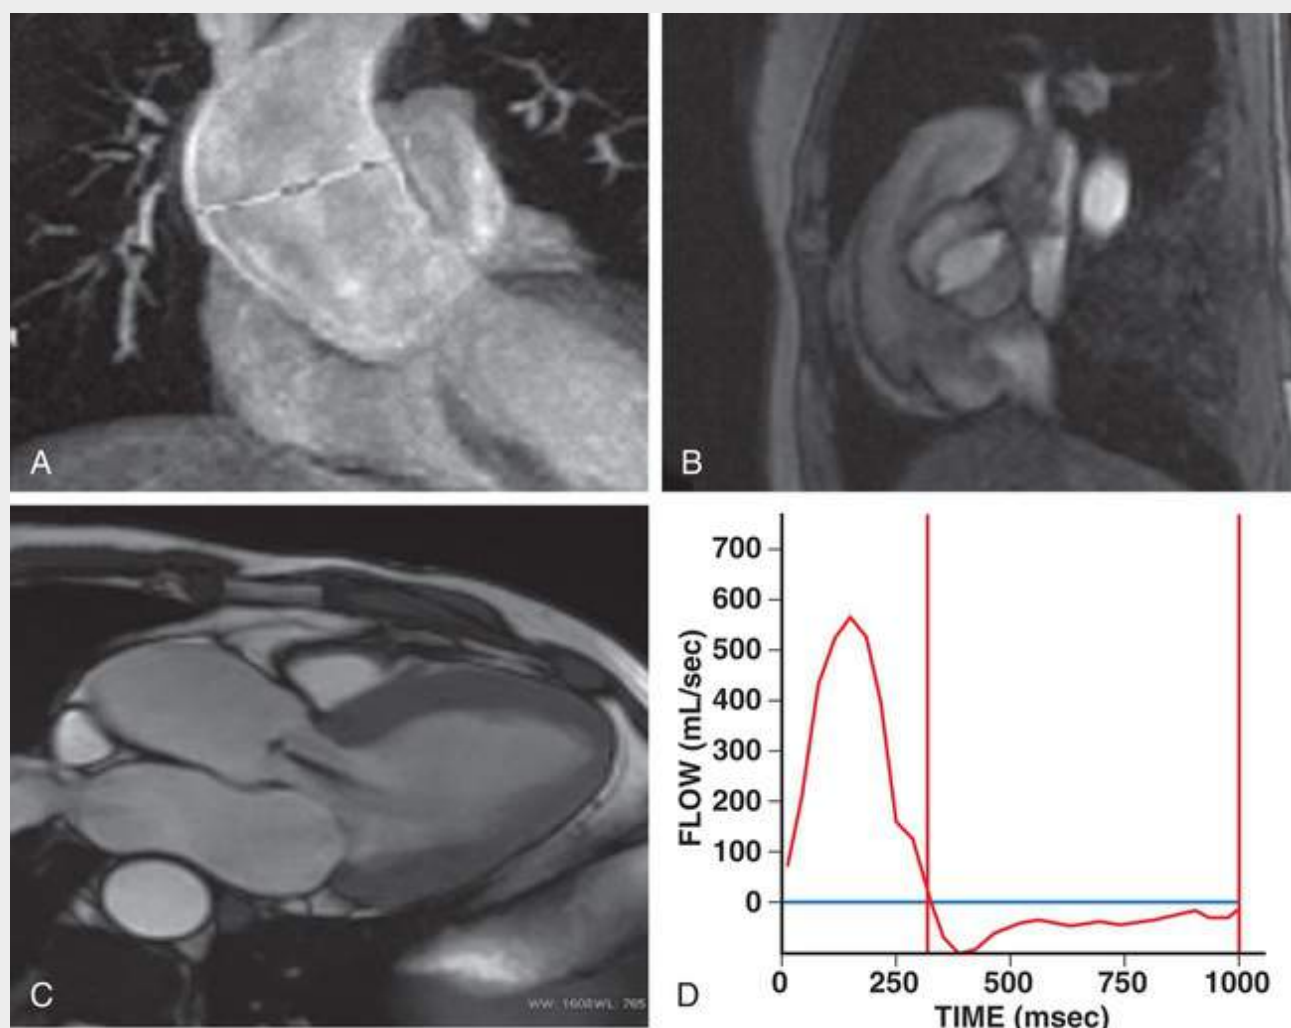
Cardiac magnetic resonance images showing a bicuspid aortic valve with aortic regurgitation and ascending aorta dilation. A, Fast single-shot steady-state free precession (SSFP) image in a coronal view. B, Retrospectively reconstructed magnitude image from a phase-contrast sequence showing a bicuspid aortic valve. C, Balanced SSFP image. Oblique axial left ventricle inflow-outflow view, showing grade 2 AR. D, Flow-versus-time plot for the ascending aorta. Antegrade flow was calculated at 140 mL/beat, retrograde flow at 40 mL/beat, and aortic regurgitant fraction of 33%. (From Tornos P, Evangelista A, Bonow RO. Aortic regurgitation. In Otto CM, Bonow RO, editors. *Valvular Heart Disease: A Companion to Braunwald's Heart Disease*. 4th ed. Philadelphia: Saunders; 2013, pp 163-78.)
